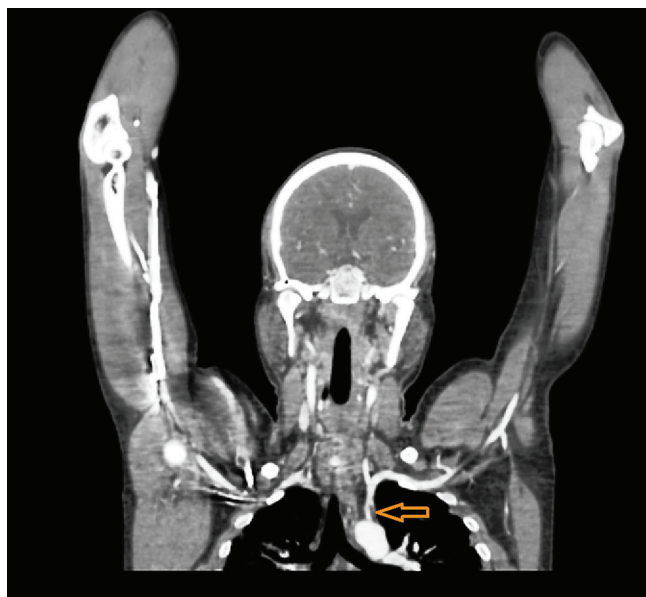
CT angiogram of patient with signs of acro-ischemia showing eccentric partial thrombus in the origin of left subclavian artery
